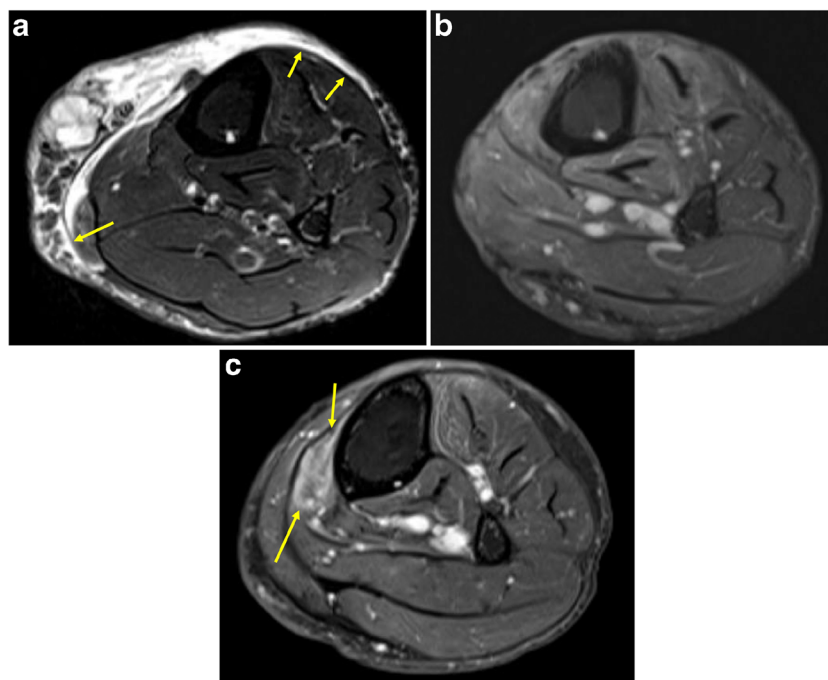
An 84-year-old woman with recurrent myxofibrosarcoma in the lower leg. a Axial T2-weighted fat-suppressed image in the lower leg shows an ill-defined mass centered in the medial aspect of the lower leg; note the infiltrative tails of peritumoral edema (*arrows*) extending across midline anteriorly, and posteromedially. Peritumoral edema or enhancement in this infiltrative fashion reflects an underlying myxofibrosarcoma growth pattern, and may thwart achievement of wide negative margins; in this case, the final closest margin was 1 mm. b Axial post-contrast T1-weighted fat-suppressed image 6 months post-operatively during routine surveillance shows changes related to medial
